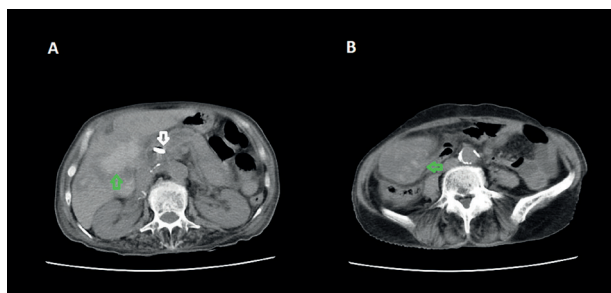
A, B: Axial abdominopelvic computed tomography scan showed heterogenic collection with septae in the subhepatic region in favor of abscess formation (green arrow). Note the common bile duct stent (white arrow).
